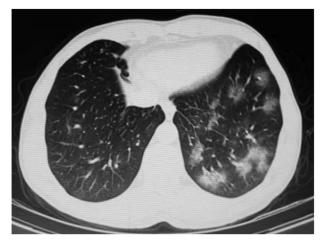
Chest CT showed bilateral peripheral ground-glass opacification.
